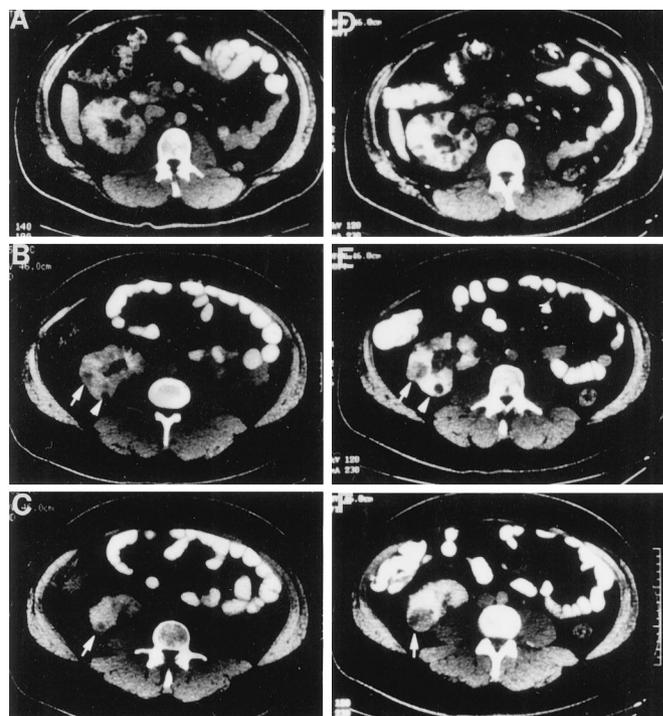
A, CT reveals many renal cysts 6 years after initial treatment. B and C, 2 small solid lesions (arrows) are visualized in lower half of kidney. D, CT shows many more renal cysts 2.75 years later. E and F, 2 small lesions (arrows) had grown to 3.0 × 2.2 and 3.0 cm., respectively. B and E, small cyst (arrowhead) remains unchanged.
